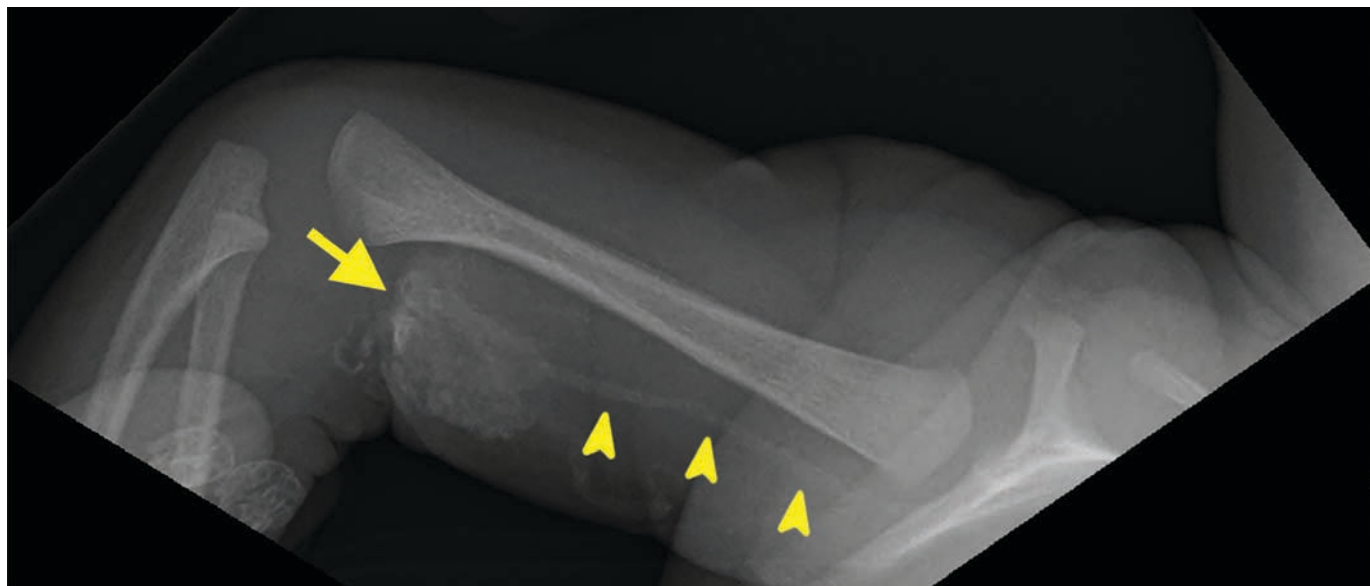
Right humeral radiograph depicts a calcific density in the antecubital region (arrow) with radiodense material coursing along a path suggestive of venous structures (arrowheads), analogous to the sonographic findings of the calcified cephalic and basilic veins.
